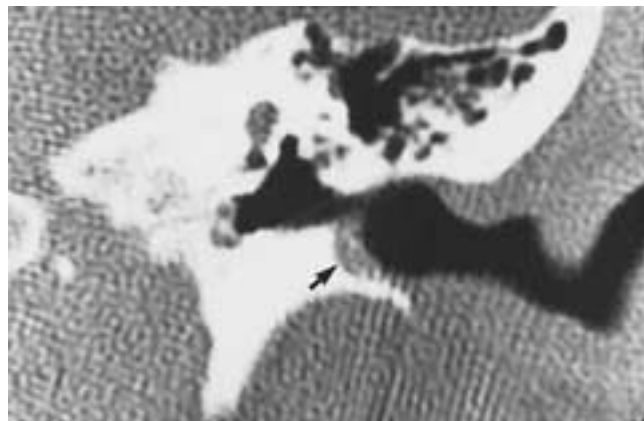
EAC cholesteatoma. Coronal CT. There is well-defined localized erosion of the inferior canal wall (arrow) lateral to the isthmus.
